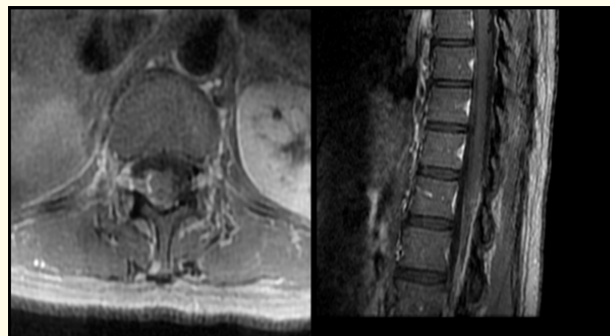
Lumbar spine MRI with contrast showing pathological contrast uptake from the meninges in the right lateral part of the conus medullaris and roots of the cauda equina indicative of arachnoiditis.
